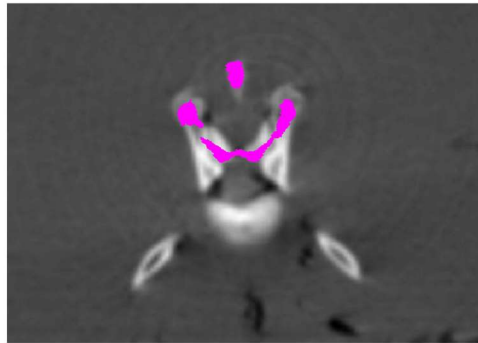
a) The registered US vertebra in magenta overlaid on the corresponding CT vertebra. The point set registration algorithm becomes incredibly more difficult with more complex geometry or ex-vivo fracture cases that could potentially misalign transformation from a particular segment.
